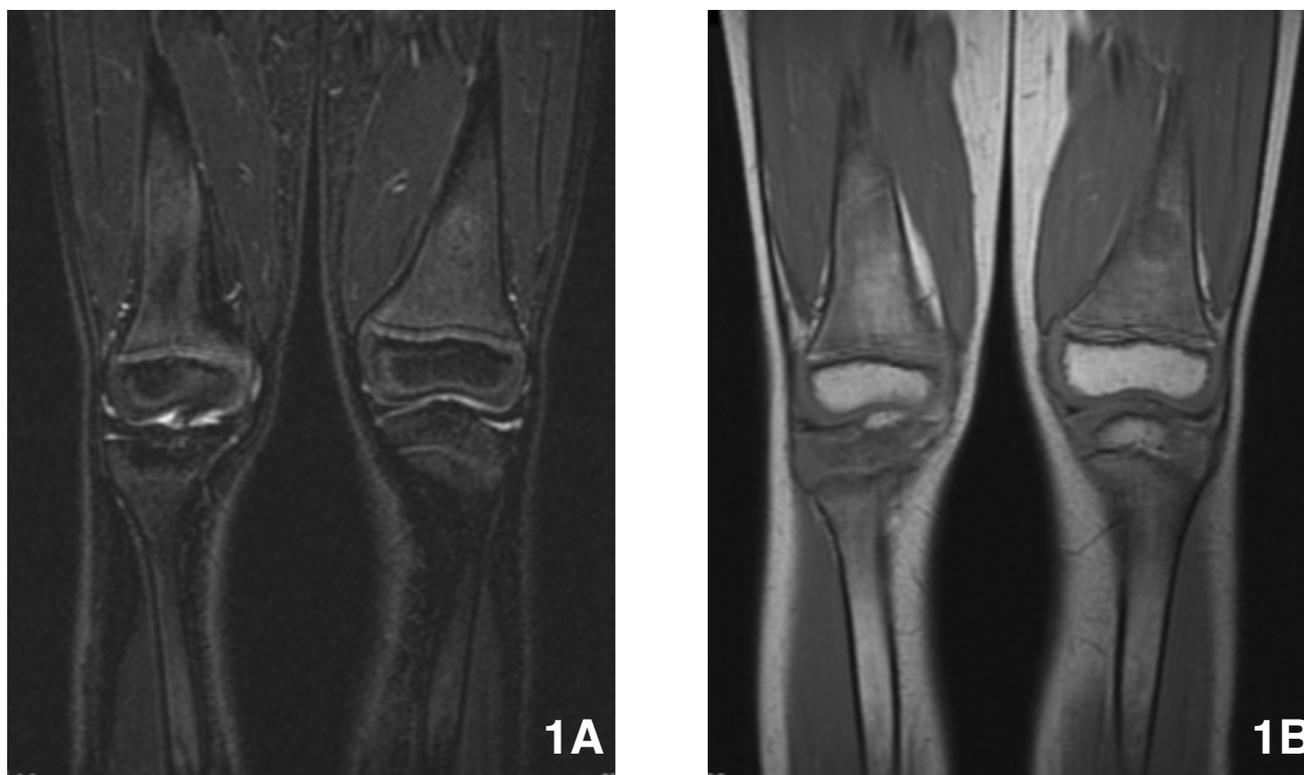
Initial study. 1A. Coronal STIR (TR 2700, TE 73) MR image shows a focal lesion in the distal left femoral diaphysis showing minimally increased signal, consistent with a treated neuroblastoma metastasis. 1B. Coronal T1 (TR 600, TE 8) MR image better depicts the intermediate-low signal treated lesion, as well as an additional, barely conspicuous lesion in the distal right femoral metaphysis.
